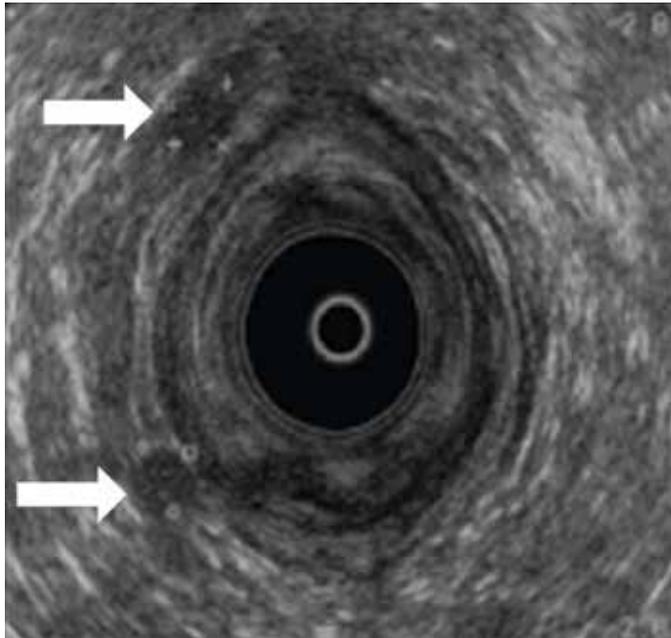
An endoanal ultrasound photo during the polyacrylonitrile injection implantation
